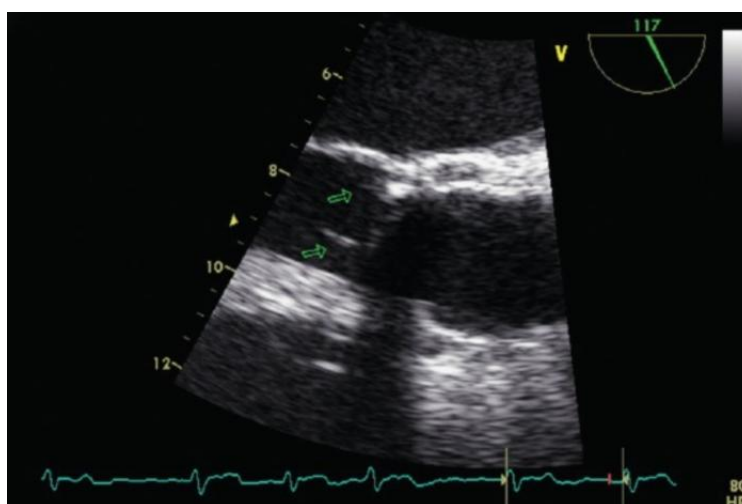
Transesophageal echocardiography of two small, mobile and echogenic filamentous vegetations (length 8mm, thickness 3mm) on the ventricular side of the aortic valve (Bentall surgery) [17]
